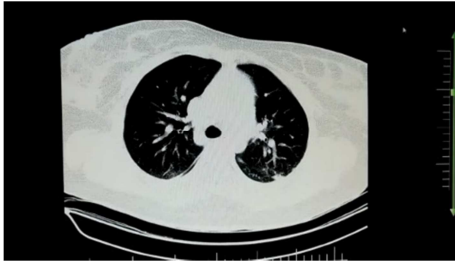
HRCT of mother of case 1,. It seems that CT findings of mother were not as severe as her clinical manifestation.
